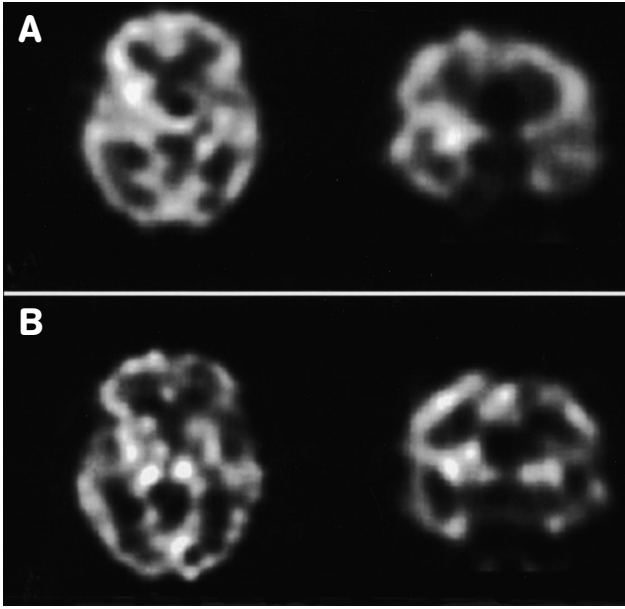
(A) cerebral SPECT, performed on the fourth post-attack day, showing decreased radioactivity at left frontal, temporal, parietal, and basal ganglion; (B) A follow-up SPECT at one month showing partial resolution at the previously hypoperfused areas.
